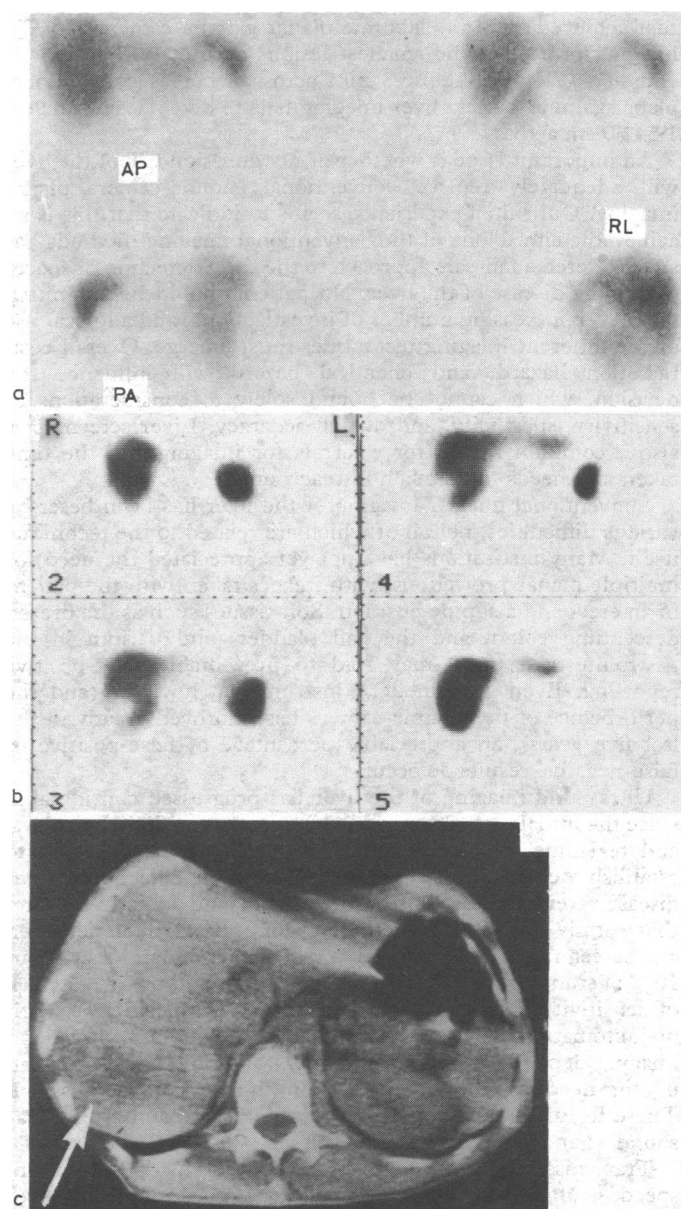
Images of liver of 56-year-old man with carcinoma of the oesophagus: (a) gamma-camera images showing single, large, well-defined defect seen best in right lateral (RL) projection; (b) emission section scan (transaxial plane) showing single well-defined defect in posterolateral aspect of right lobe of liver; (c) abdominal x-ray CT scan showing defect in posterolateral aspect of the right lobe of the liver (arrowed).
